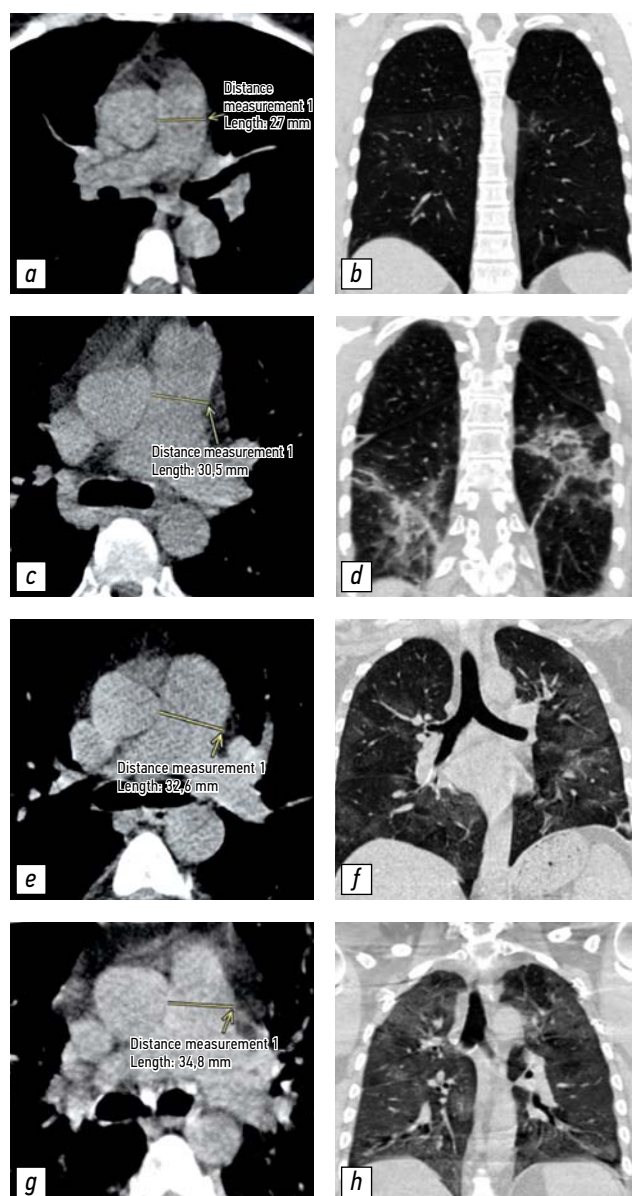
Examples of CT scans with different PA diameters and lung lesion degrees: a, b, non-dilated PA (27.0 mm) with CT-1 lung lesion (<25%); c, d, dilated PA (30.5 mm) with CT-2 lung lesion (25%–50%); e, f, dilated PA (32.6 mm) with CT-3 lung lesion (50%–75%); g, h, dilated PA (34.8 mm) with CT-4 lung lesion (over 75%). CT: computed tomography; CT 1–4: adapted scale for visual assessment of the relationship between the patient's general condition severity and the nature and intensity of radiological signs of pulmonary changes in COVID-19; PA: pulmonary artery.
